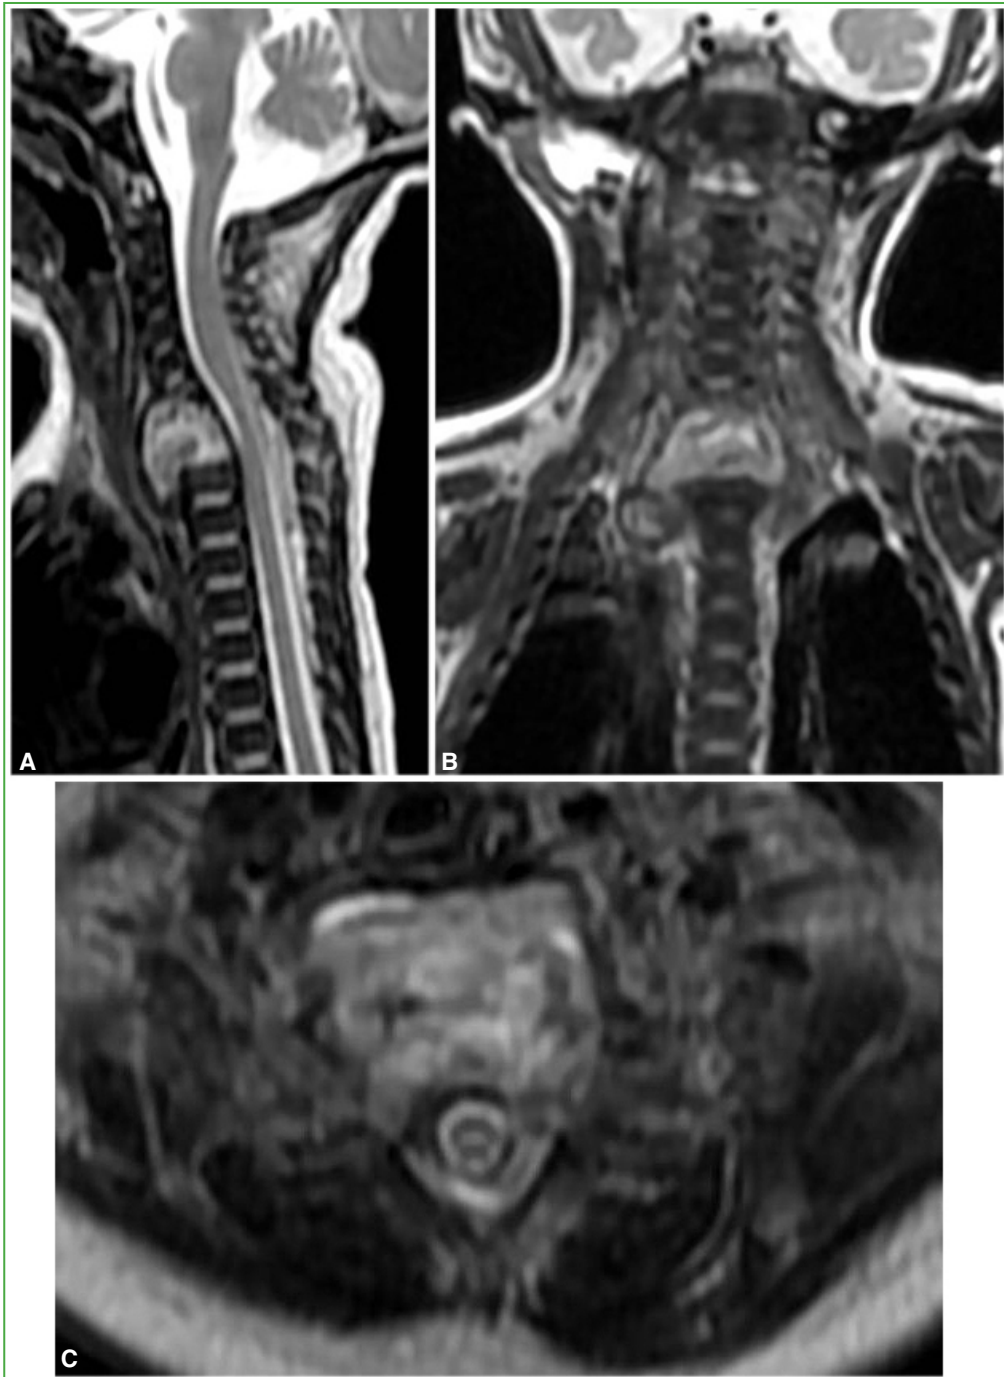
Magnetic resonance imaging of the neck. The abscess and the disappearance/destruction of vertebral bodies can be appreciated with greater fidelity. A. Sagittal view. B. Coronal view. C. Axial view.
